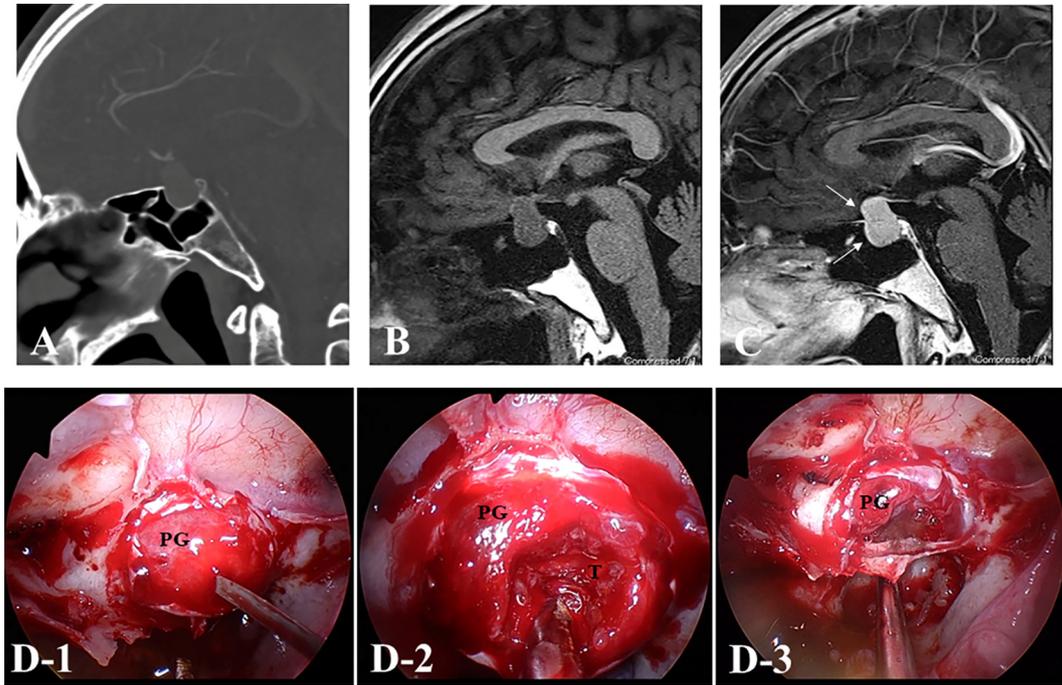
Preoperative sagittal (A) computed tomography (CT) shows an iso-dense mass in the sellar region accompanied by expansion of the sellar turcica. T1-weighted (B: sagittal view) and gadolinium (Gd)-enhanced T1-weighted (C: sagittal view) magnetic resonance imaging (MRI) reveals a tumor mass in the sellar region extending into the suprasellar region. The tumor is homogeneously enhanced to a high degree with Gd. Enhanced anterior pituitary gland is displaced anteriorly (white arrows), and hyperintense on T1WI which suggested posterior pituitary is disappeared. Intraoperative findings from endoscopic trans-sphenoidal surgery (PG: pituitary anterior gland; T: tumor). D-1) Endoscopic view during operation showing the normal anterior pituitary gland located immediately under the bottom of the sella turcica. D-2) The tumor placed below the anterior pituitary gland. Macroscopic examination showed a solid, rubbery-firm consistency and hypervascularity. D-3) The tumor originated from the posterior pituitary gland and had a clear margin between the anterior pituitary. We achieved gross total resection of the tumor.
